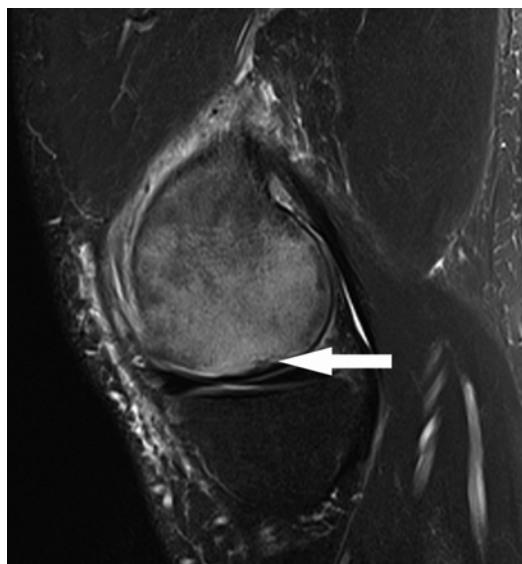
T2 sagittal MRI image of a subchondral insufficiency fracture with subchondral collapse of the medial femoral condyle in a previously active 64-year-old male. Note the significant bone marrow edema and subchondral collapse indicated by the arrow. Image courtesy of Joanna Costello, M.D.
